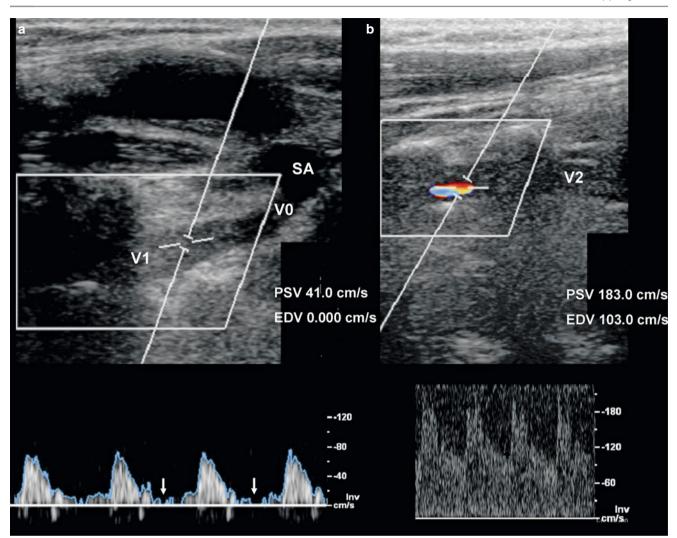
Two case examples. (a) A high-resistance flow in the proximal VA indicates a severe obstruction distally in a patient with an atherosclerotic VA occlusion. Note that there is no end-diastolic flow on Doppler
